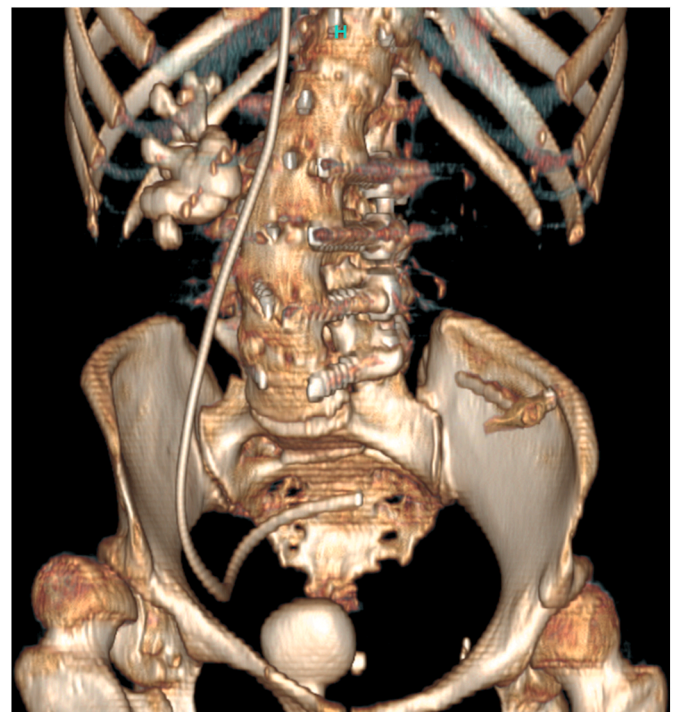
3D reconstruction of the CT scan.
